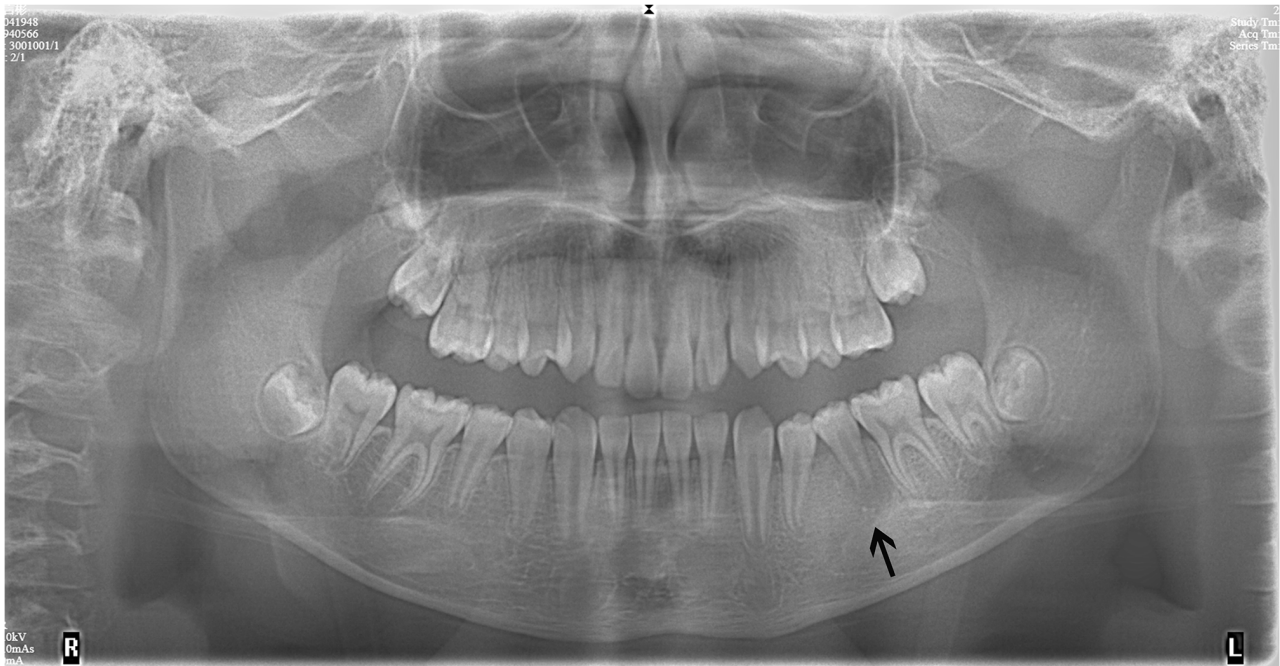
Preoperative panoramic radiograph of case 1. Tooth 20 demonstrated extensive mid-root resorption, resulting in detachment of the apical fragment (black arrow) and a subtle adjacent radiolucency.
